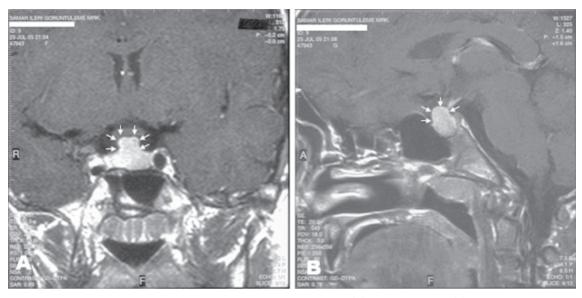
Pretreatment MRI of the pituitary gland. T₁-weighted coronal (A) and midsagittal (B) views of the pituitary demonstrating a large homogeneously enhancing sellar lesion with suprasellar extension (white arrows).
